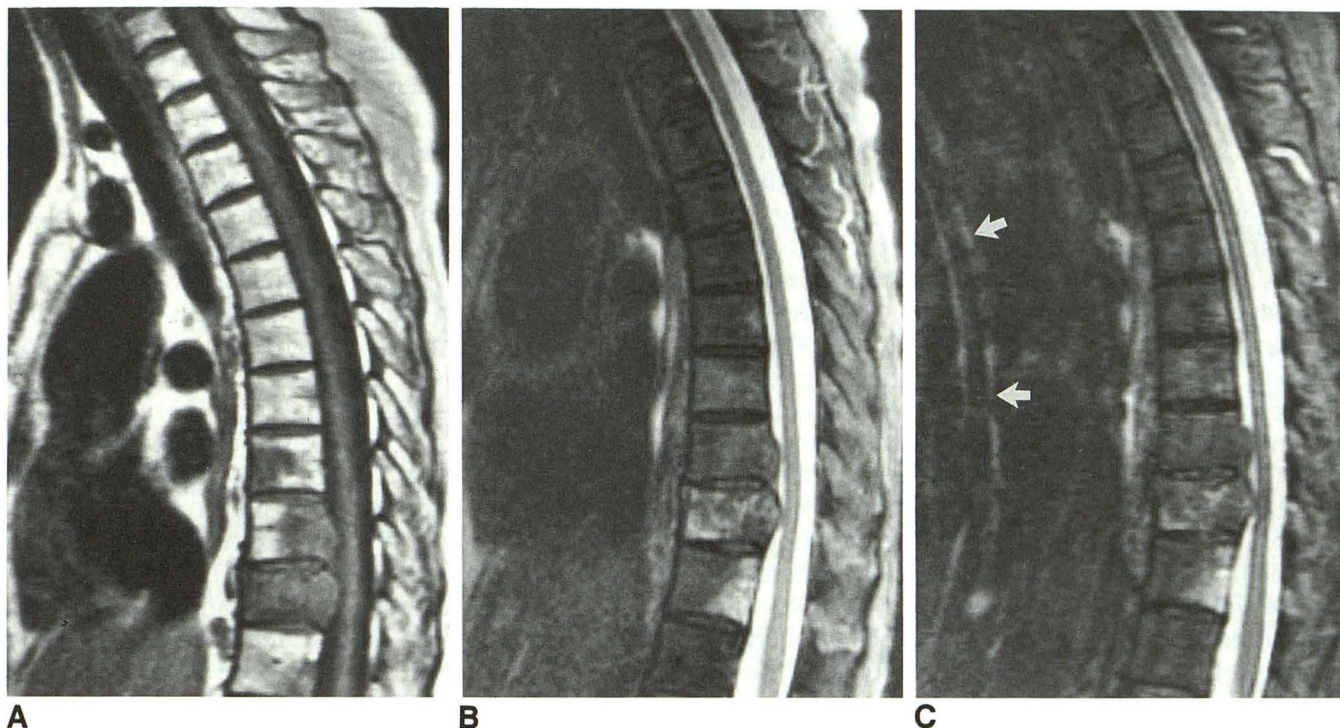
A, T1-weighted fast spin-echo image of the thoracic spine in a patient with metastatic adenocarcinoma of unknown primary. Lesions are well seen, but the spinal cord shows suboptimal anatomic detail. B, T2-weighted fast spin-echo image with fat suppression shows improved cord detail. Posterior extent of lesions is well seen. C, STIR fast spin-echo image with identical findings. Note bright cerebrospinal fluid-related artifact (*arrows*).
